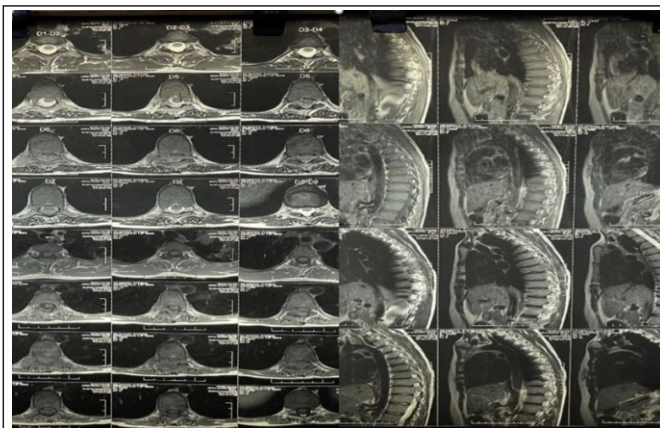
Pre-operative MRI of axial and sagittal view.
